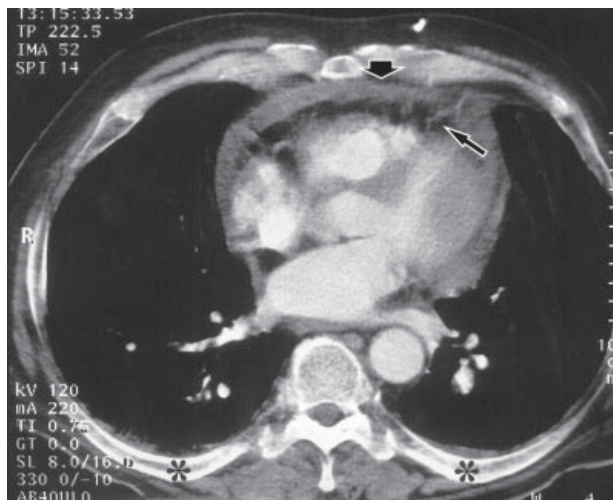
Spiral thoracic post-contrast computed tomography scan at the level of the superior pulmonary vein entrance to the left atrium. An effusion of 10 mm maximum thickness (thick arrow) is seen, with stranding of the epicardial fat (thin arrow). Similar, although less pronounced, features are seen in the adjacent ventral mediastinal fat. Small bi-basal pleural effusions are seen immediately anterior to the ribs (asterisks). The subcutaneous fat planes are normal in appearance.
